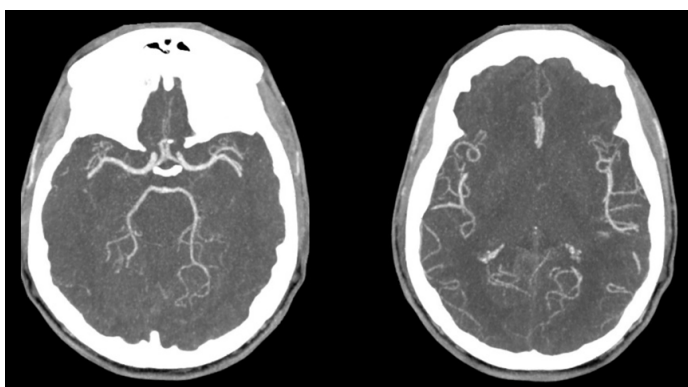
Axial CT maximum intensity projection (MIP) reformats of the head demonstrating patency of the major intracranial arteries.
